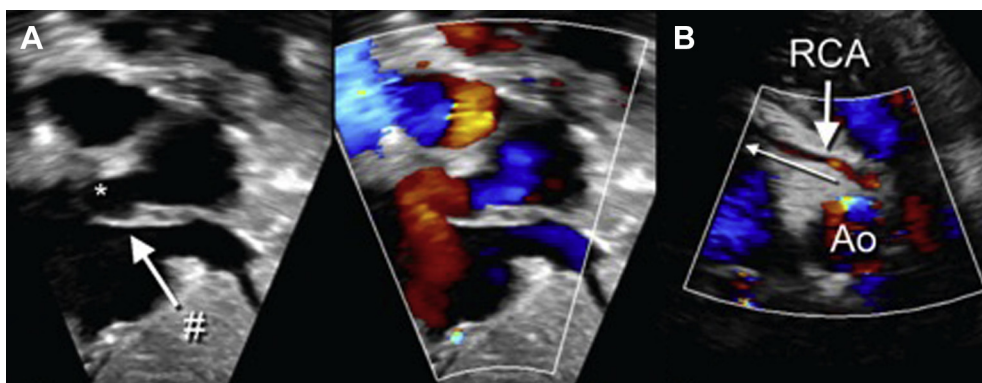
Postoperative transthoracic echocardiography before patient discharge. (A) Subcostal sagittal view demonstrates the patch (pound sign) that baffles the right upper pulmonary veins (asterisk) back into the left atrium. (B) Reimplanted right coronary artery (RCA) with antegrade flow from the aorta (Ao) into myocardium.
